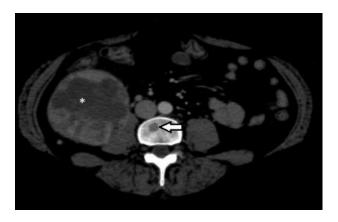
Contrast enhanced CT scan axial slice in bone windows showing osseous metastasis.
